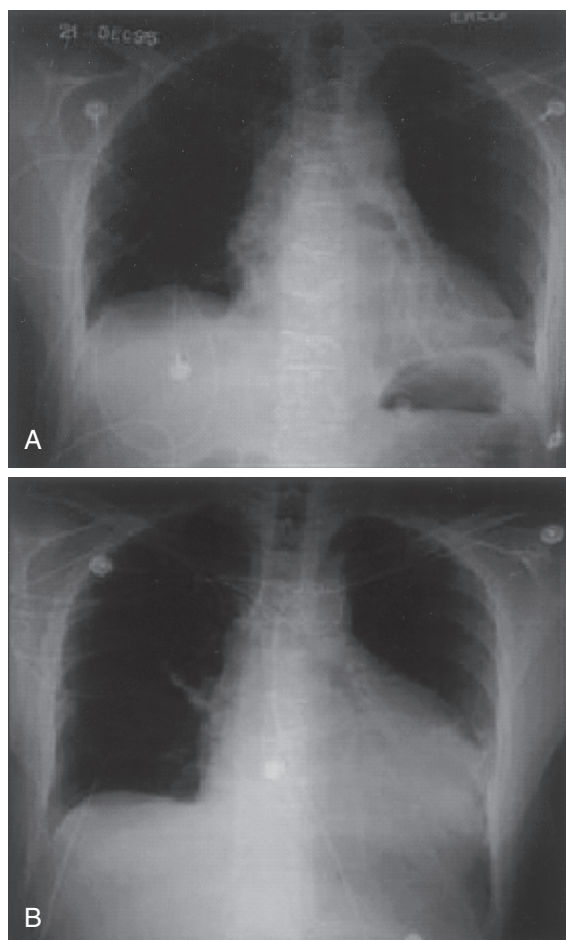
■ Post-pericardiotomy syndrome is commonly associated with pericardial and pleural effusions. A, Chest radiograph on a patient soon after aortic valve replacement shows expected postoperative findings. B, Chest radiograph 2 weeks later shows pericardial effusion compatible with the clinical symptoms of post-pericardiotomy syndrome.
